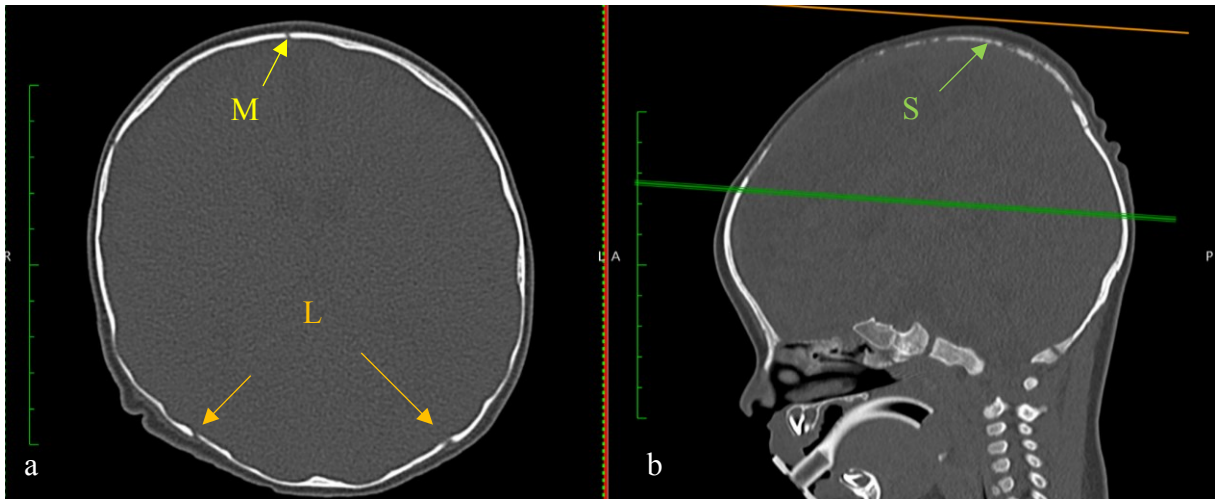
CT image of a pediatric skull of a 3 months old male in bone window showing assessed sutures of the skull cap in, a axial view and b sagittal reformat (yellow arrow: metopic suture, orange arrows: left and right lambdoid suture, green arrow: sagittal suture).
